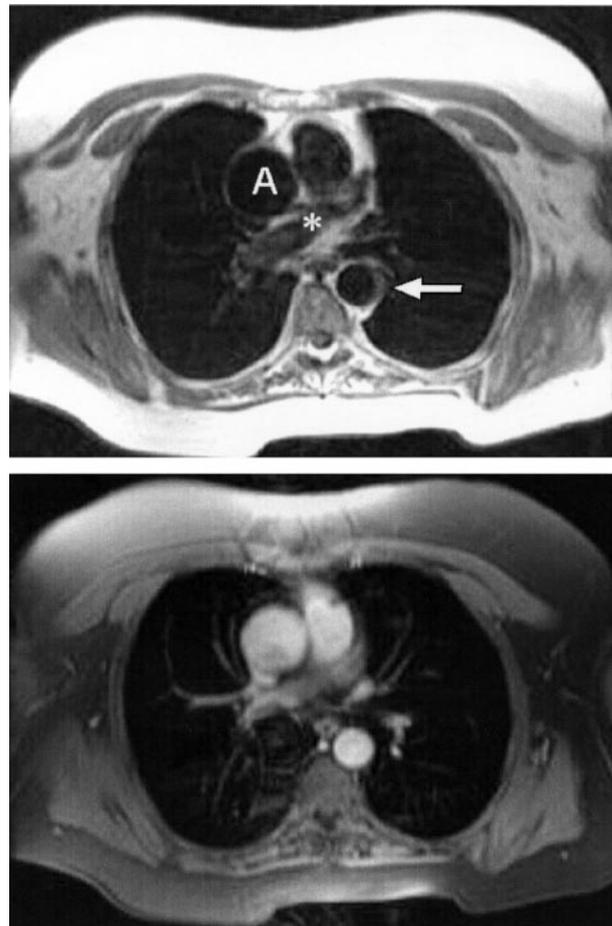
Magnetic resonance imaging of ascending and descending aorta. Top, Axial “black-blood” fast spin-echo demonstrates ascending aorta (A; diameter, 3.7 cm) and descending aorta (arrow, 2.2 cm) at the level of right pulmonary artery (*). Bottom, Axial “bright-blood” postgadolinium spoiled gradient-echo image obtained at the same level as above.
